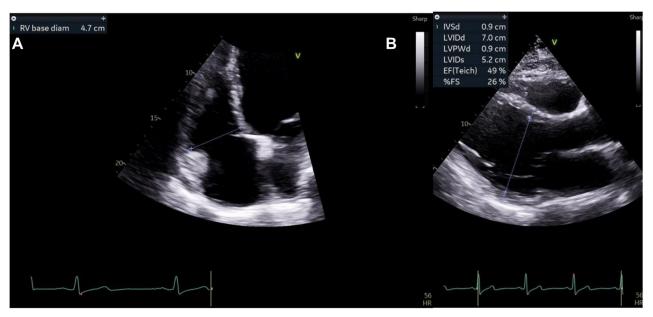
Baseline two-dimensional TTE, apical 4-chamber RV-focused (A) and parasternal long-axis (B) diastolic views, demonstrates biventricular dilation.
